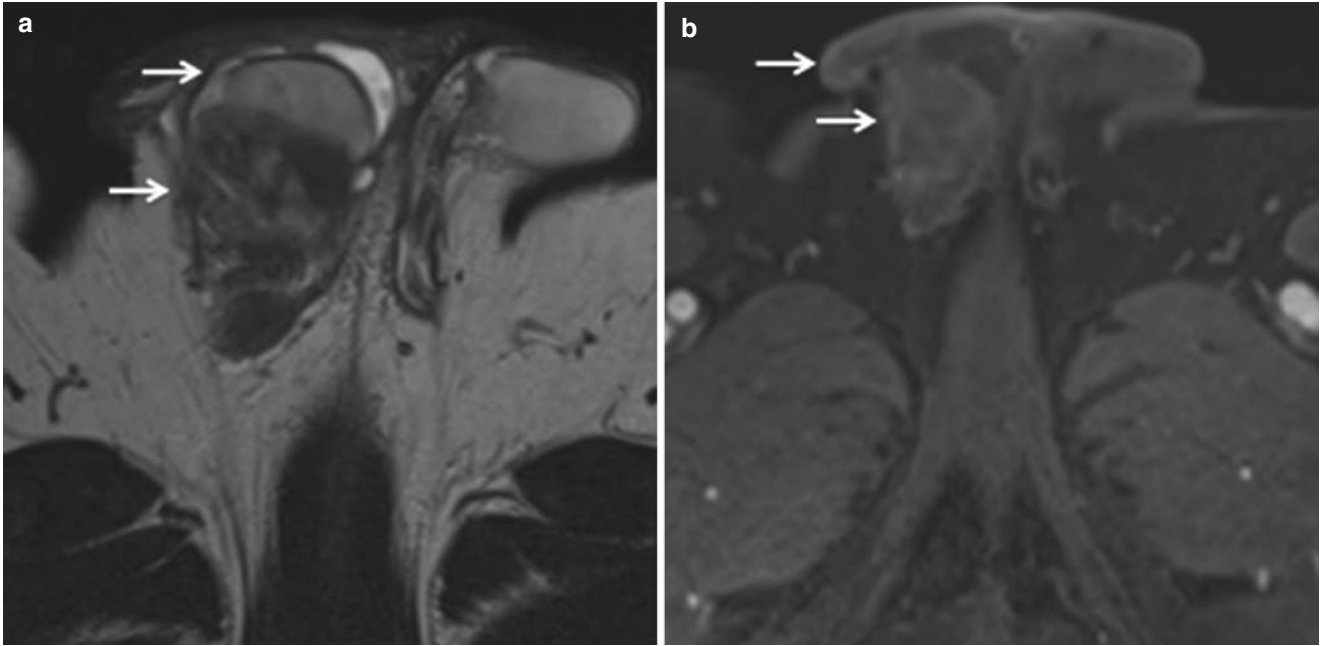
Epididymitis-orchitis in a 28-year-old man with acute right scrotal pain. Axial (a) T2-weighted MR image shows heterogeneous increased signal intensity of the right testis compared with the left
